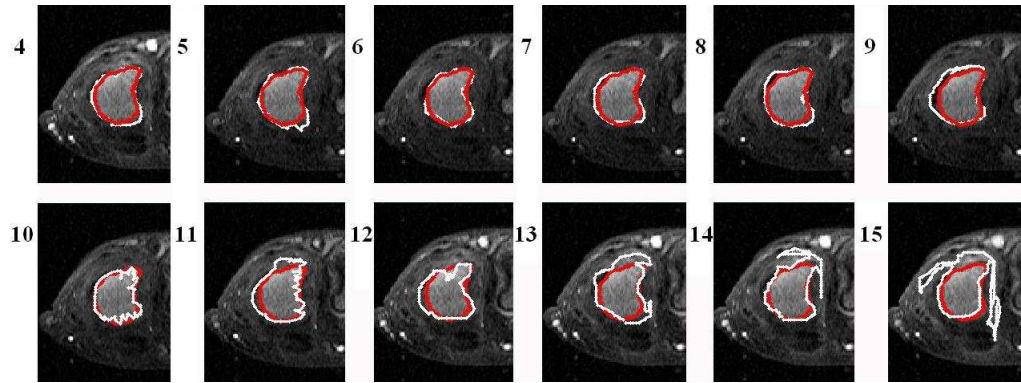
A bone interiors segmented by the region growing algorithm in the images from a sample DCE-MRI temporal slice acquired by the high-field scanner; images were acquired between  $T_4$  and  $T_{15}$  time instants. Intensity change in the tissues surrounding the bones is noticeable. Machine segmentations are shown in white, GT – in red.
